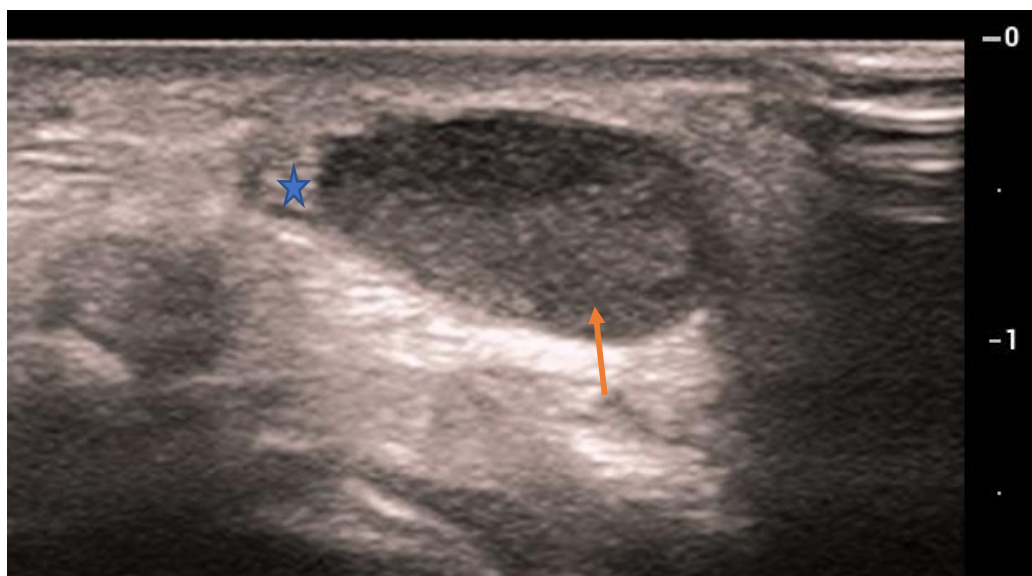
Ultrasonography Showing an Ovalar Well Circumscribed Hypoechoic Mass (↗) Depending on the Peripheric Part of the Median Nerve (*).
